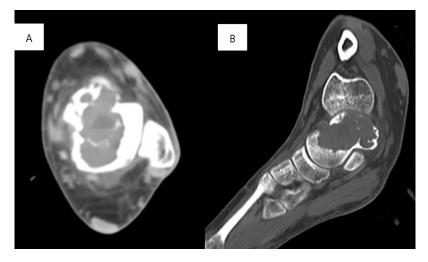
(*A*) Axial and (*B*) sagittal computed tomography images of the left foot demonstrating a 2.5 × 4.1 × 2.9-cm, lobulating, well-circumscribed osteolytic mass in the talus. The mass shows cortical disruption and extraosseous extension at the anterosuperior aspect.
